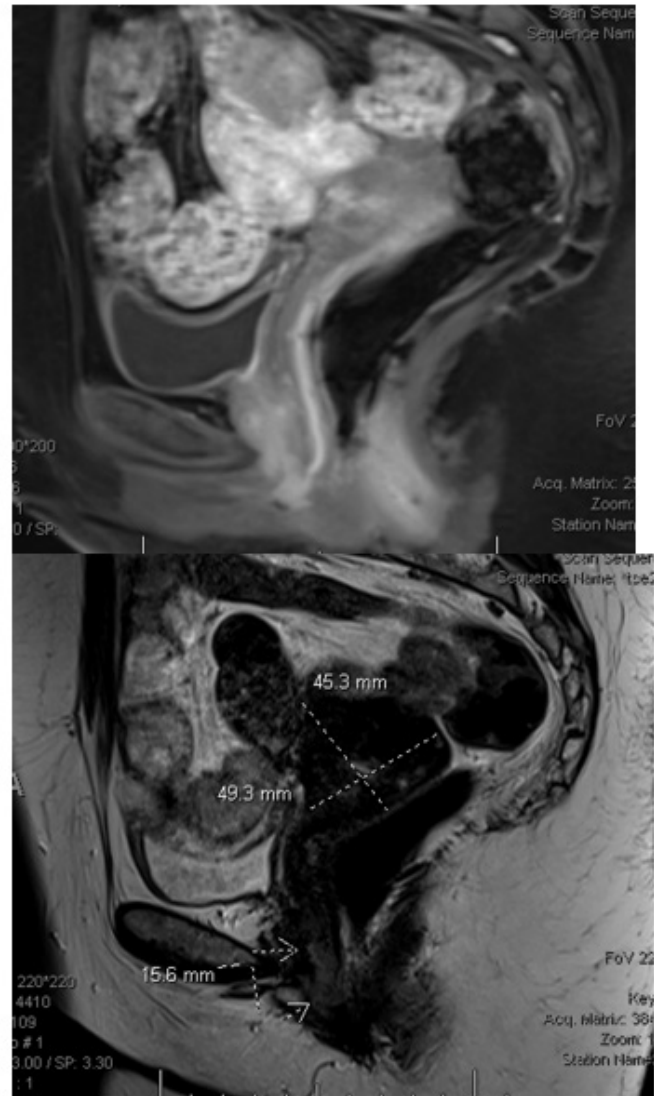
MRI pelvis with and without intravenous contrast after 6 cycles R-CHOP.
